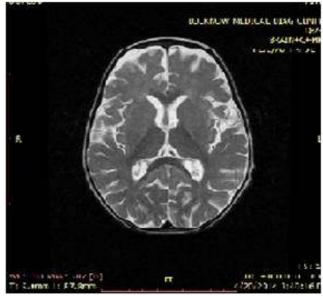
T2W Axial and FLAIR image showing hyperintense signal in peri and supraventricular white matter especially near bifrontal horn.
